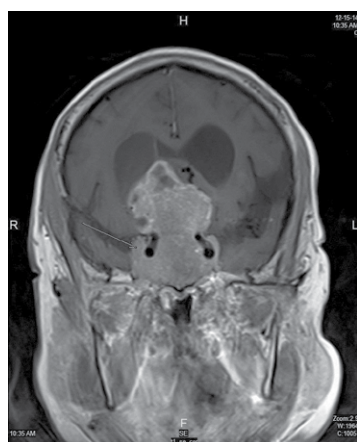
MRI/T1 (coronal view) showing pituitary mass (suggestive of macroprolactinoma) with bony destruction and compression of optic chiasm.
